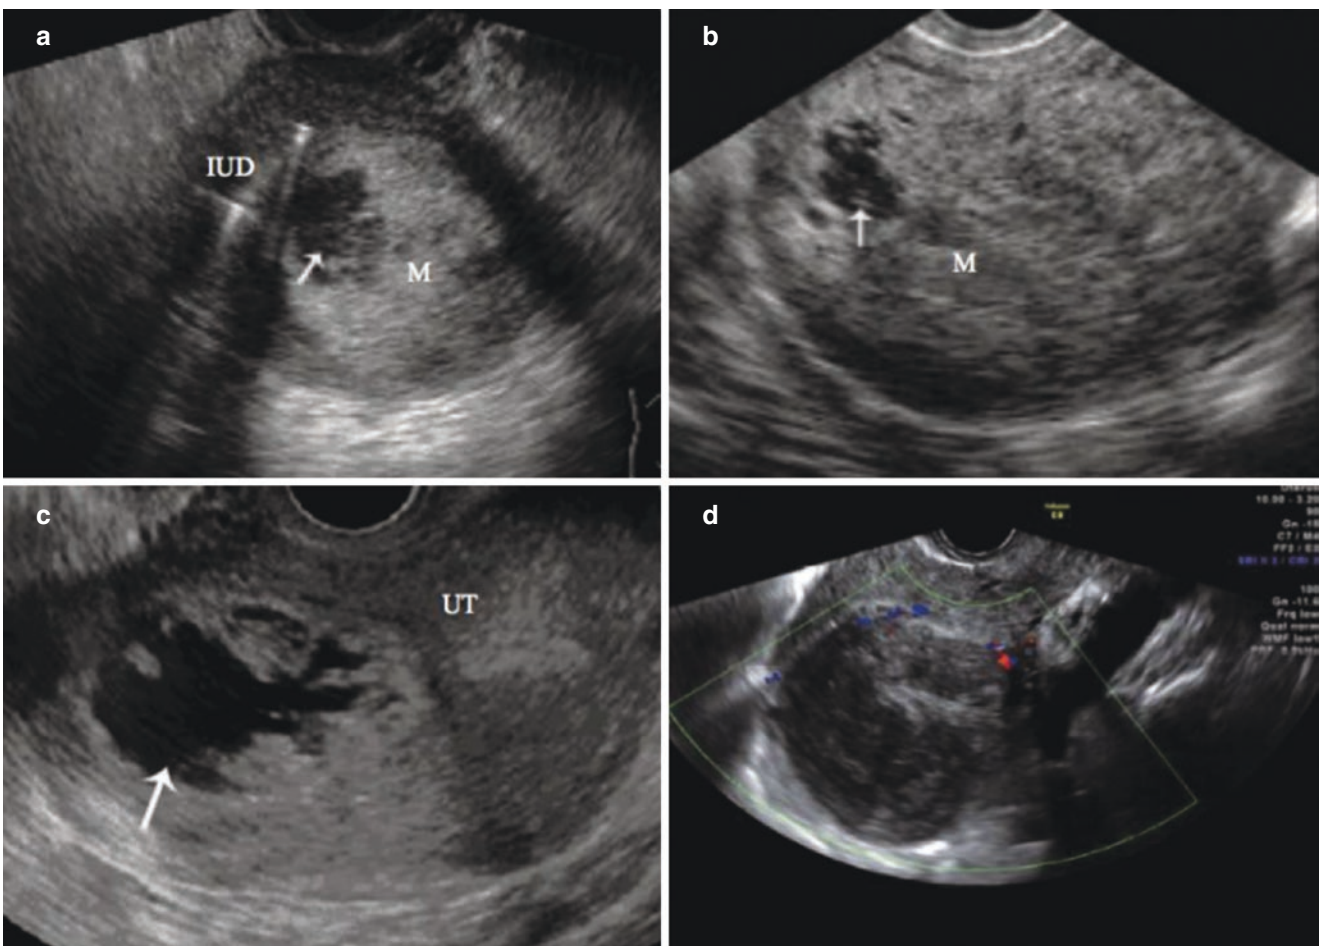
Degenerated leiomyoma. (a-d) Different degrees of hydropic degeneration of the fibroids. Sonogram shows the heterogeneous leiomyoma with irregular fluid areas (arrow)
